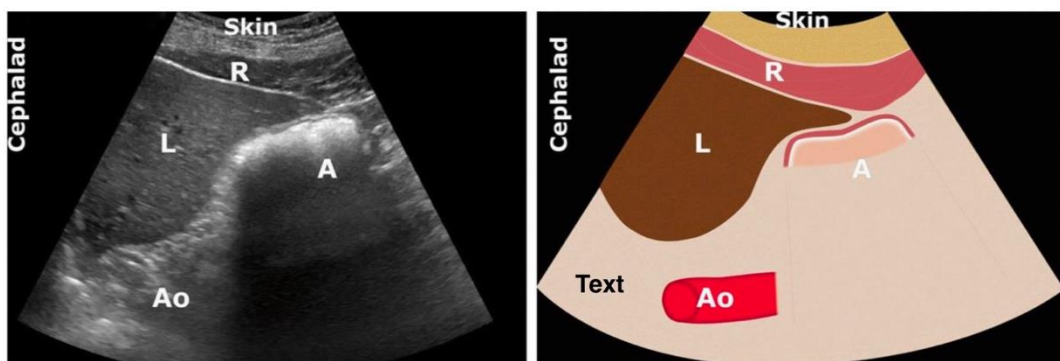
Ultrasound image showing solid gastric contents with a “frosted glass” appearance. R – Rectus abdominis muscle, A – Antrum, Ao- Aorta, L - Liver
